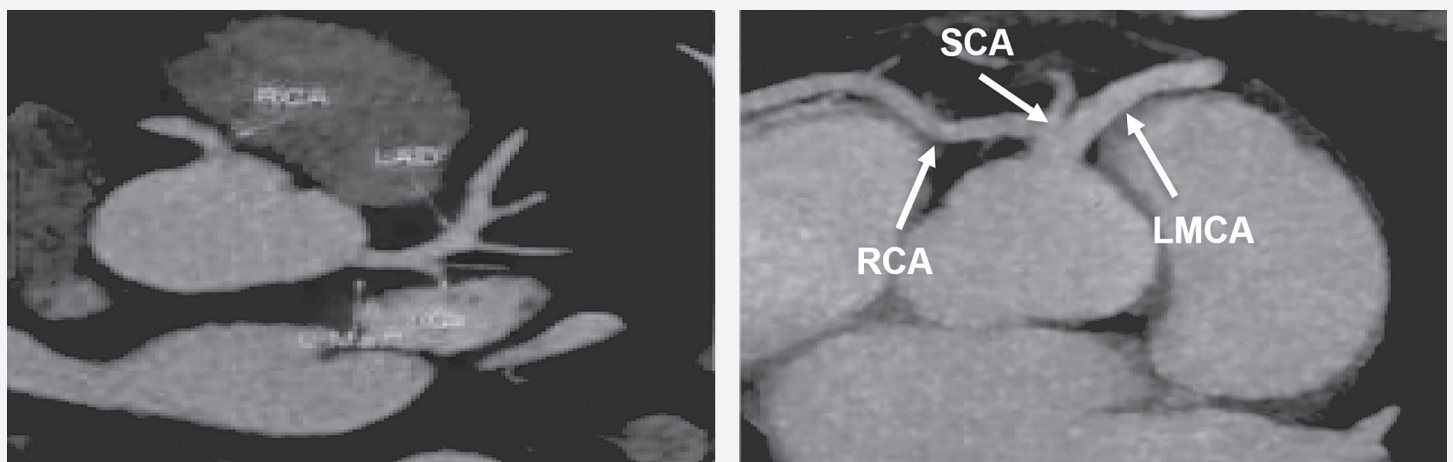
The picture on the left shows the normal configuration of the coronary arteries. The picture on the right is the CT coronary angiogram of the patient showing a single coronary artery (SCA) arising from the right aortic sinus and bifurcates into the right coronary artery (RCA) and left main coronary artery (LMCA)
